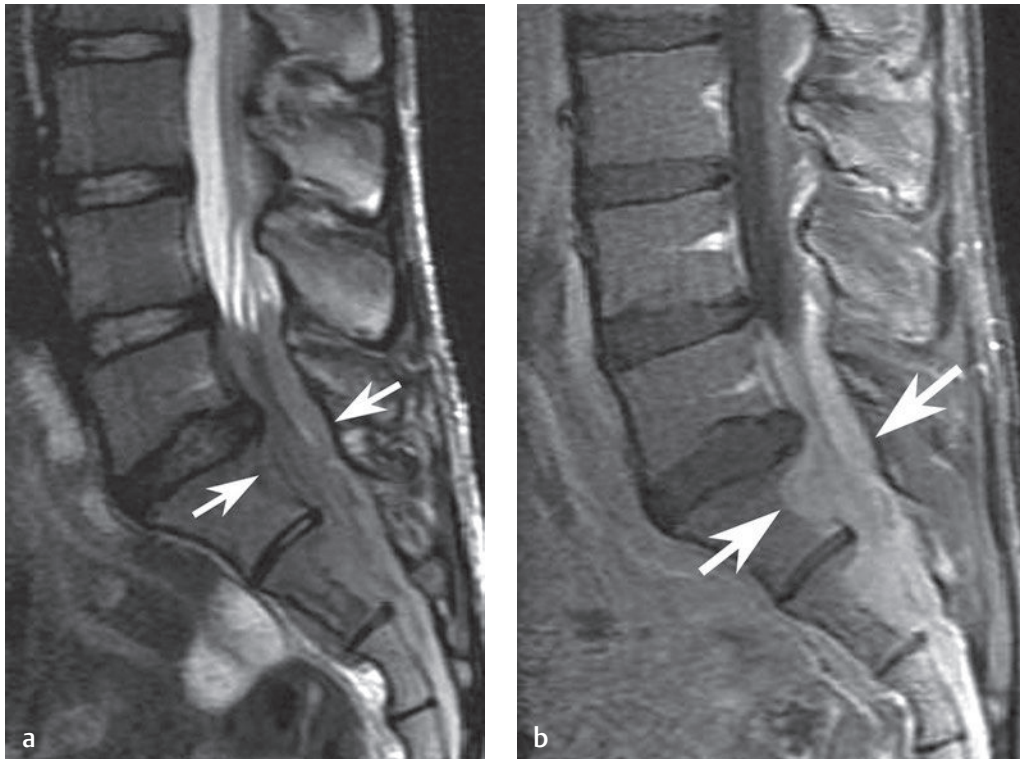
Epidural B-cell lymphoma surrounding and compressing the caudal thecal sac in the lumbosacral spine. (a) On a sagittal T2-weighted image, the lesion is isointense compared with the nerve roots and fills the spinal canal, expanding the canal at S1 (arrows). (b) On a sagittal postgadolinium T1-weighted image, the lesion (arrows) shows robust enhancement.[†]
